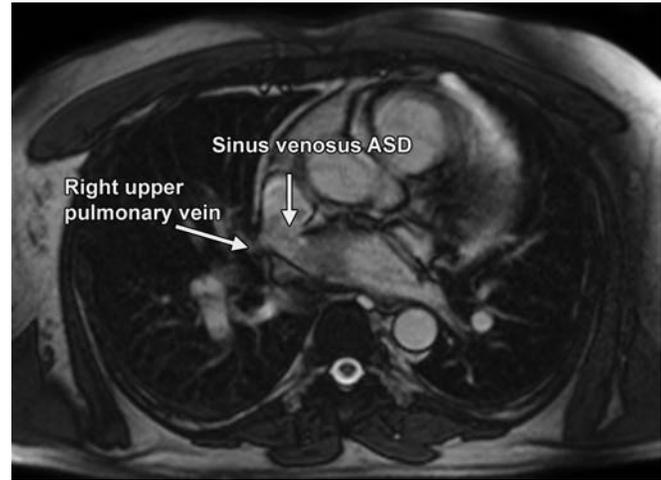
Magnetic resonance imaging showing the defect and right upper pulmonary vein.
